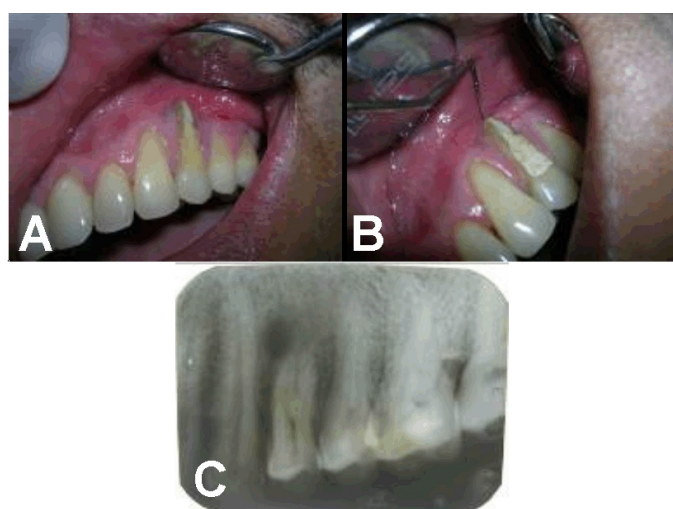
(A) Millers class III MTR in 24, (B) Complete exposure of buccal root beyond apex, (C) Periapical radiolucency in relation to 24.
